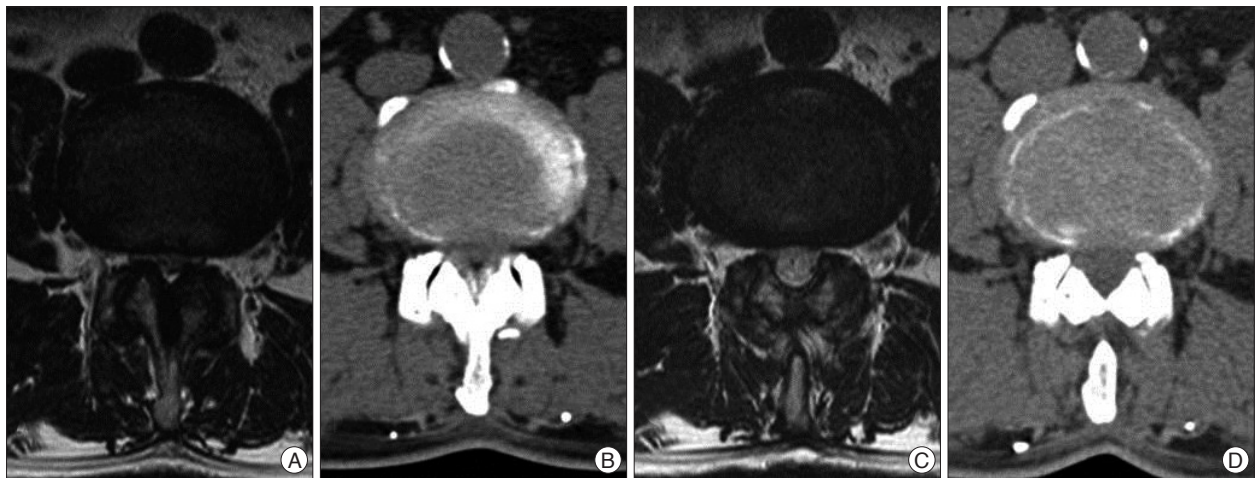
At the L4/5 level, preoperative axial T2-weighted (A) and CT (B) images show spinal stenosis. Postoperative axial T2-weighted (C) and CT (D) images show the spinal canal decompressed by bilateral laminotomy.
